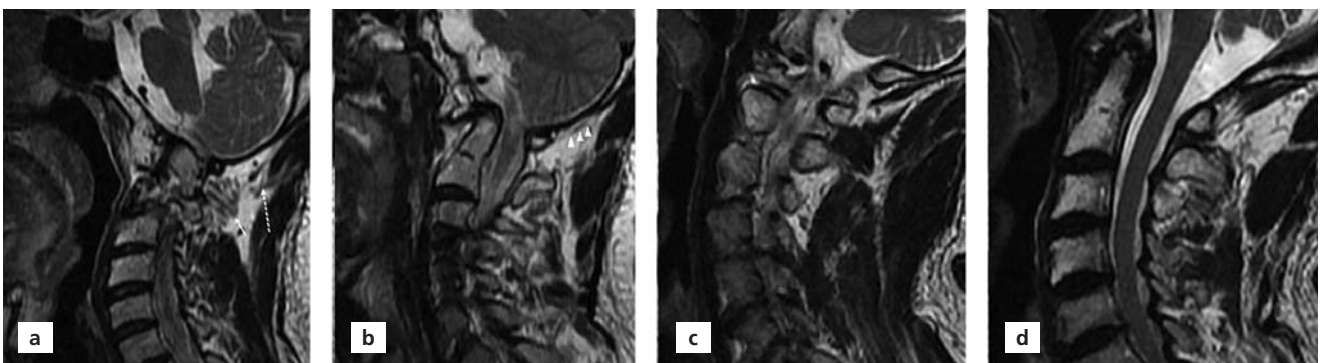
(a) A 52-year-old female with AOA. Sagittal T2-weighted MR images representing severe atrophic changes of rectus capitis posterior major (short arrow) and obliquus capitis inferior muscles (long arrow). (b) Nearly absence of rectus capitis posterior minor muscle (arrowheads). (c) Normal rectus capitis posterior major-minor (d) Obliquus capitis inferior muscles in a 52-year-old female on sagittal T2-weighted MR images.
